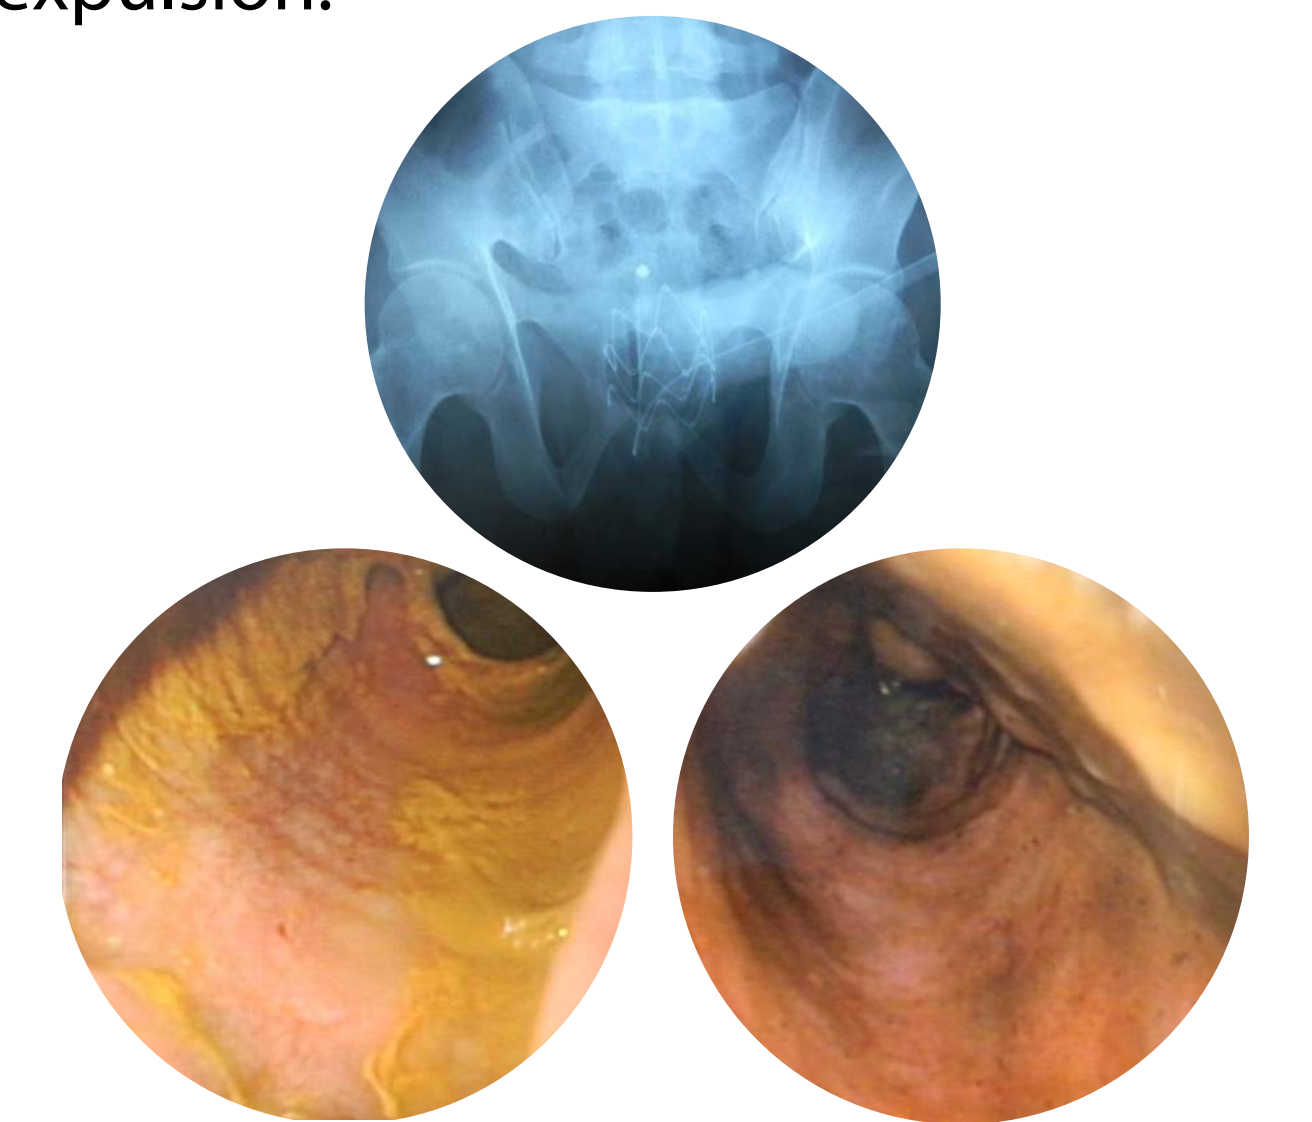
X-ray was done to confirm correct deployment; pre/post sigmoidoscopy to confirm mucosal health
